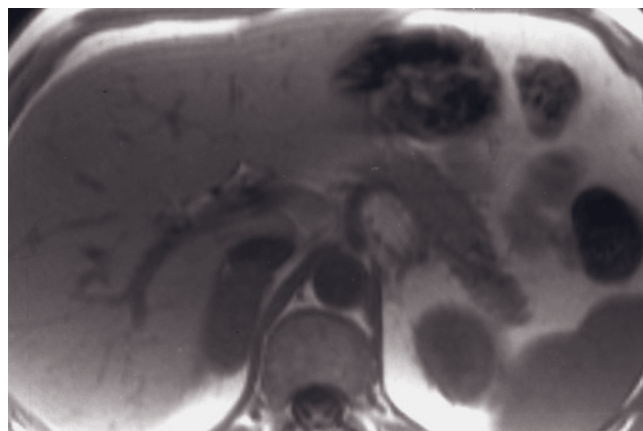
Large left adrenal metastases. T1-weighted GE (a), T1-weighted out-of-phase GE (b), T2-weighted fat-suppressed spin-echo (c), immediate postgadolinium (d), and 3-min postgadolinium GE (e) images. A large 8-cm left adrenal metastasis is identified that retains signal intensity from in-phase (a) to out-of-phase (b) images. The mass is heterogeneous and moderately high in signal intensity on T2-weighted images, with a central high-signal-intensity region (c). On immediate postgadolinium image (d), the mass enhances minimally. On more delayed images, a central low-signal-intensity signal-void region compatible with necrosis is identified (arrow, e) that corresponds to the region of high signal intensity on T2-weighted images. The central necrosis and heterogeneity demonstrated on T2-weighted and postgadolinium images further confirm the findings of a malignant mass on out-of-phase images. Distinction between adrenal metastasis and left kidney is best defined on the immediate postgadolinium GE image by the demonstration of corticomedullary differentiation of the kidney (arrow, d).
